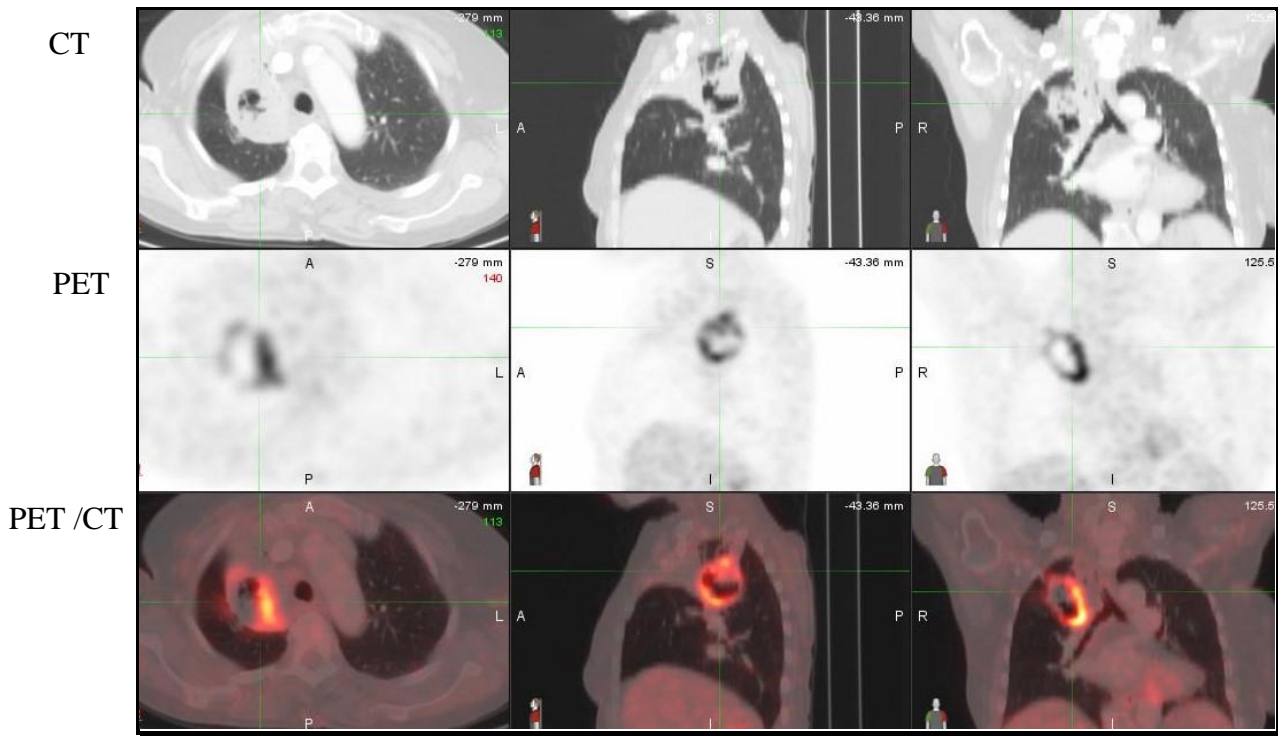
Axial, sagittal, and coronal CT, PET, and PET/CT images showing metabolic active right upper lobe thick-walled cavitory lung lesion.
